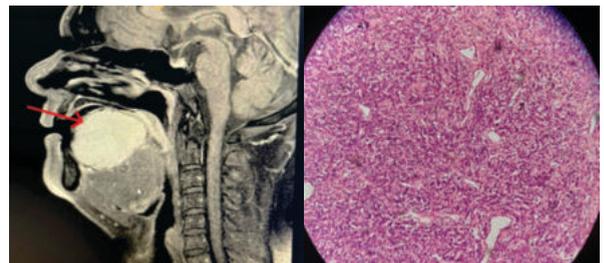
B: MRI tongue Saggital plane
